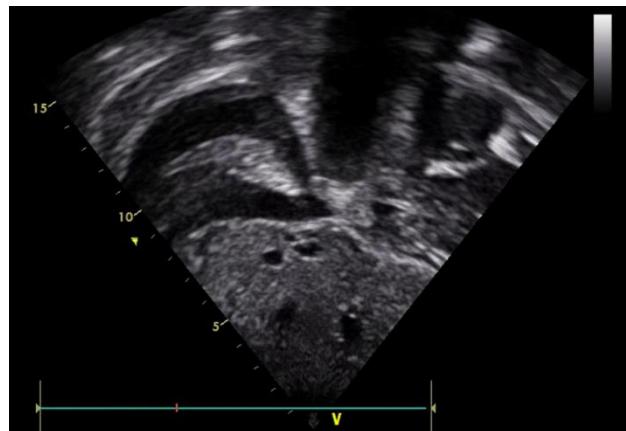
2D echocardiogram showing subcostal transverse view. The is moderate to severe right sided pleural effusion.
